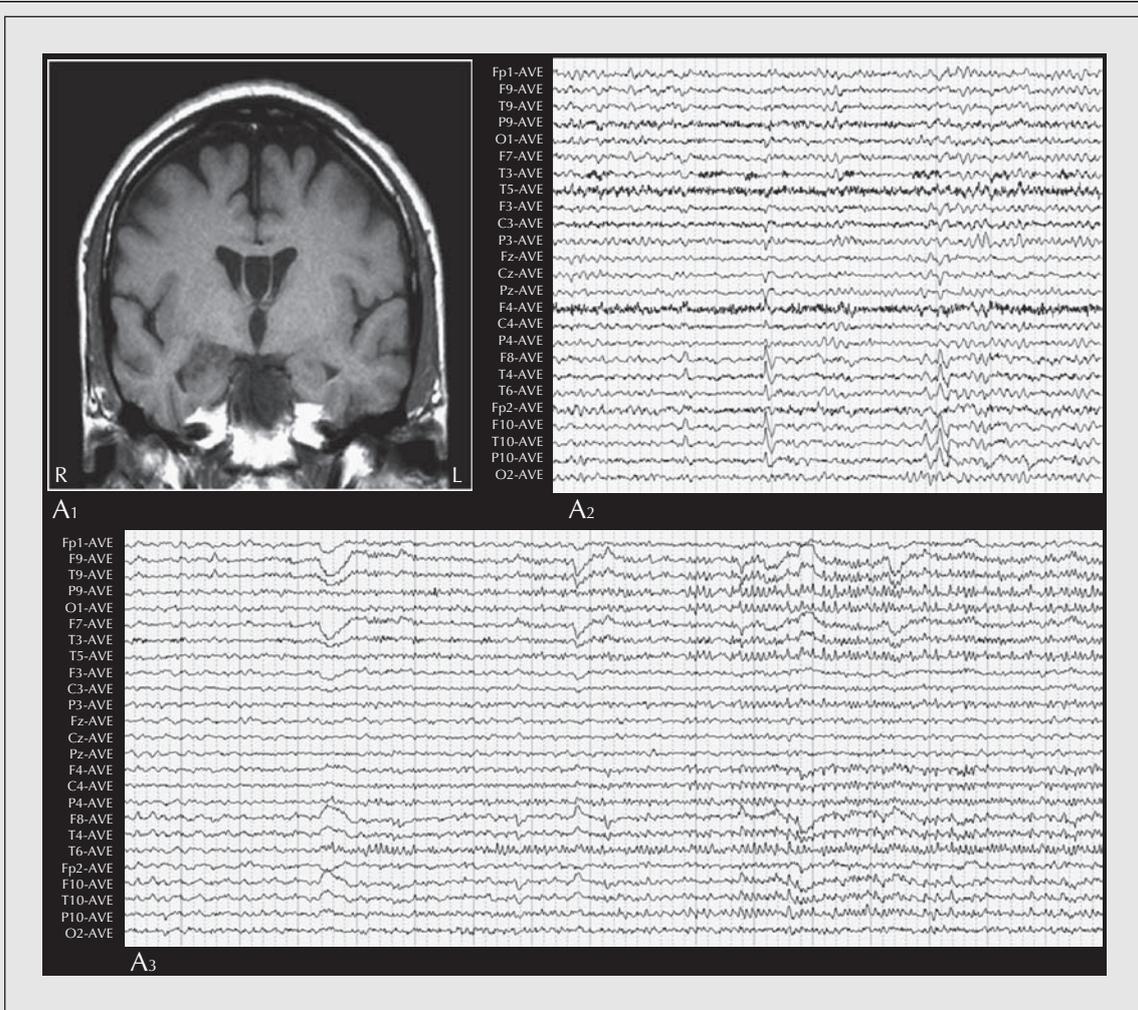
Patient 7. (A₁) MRI revealed a right medial temporal lobe mass lesion. (A₂) Interictal EEG shows a right anterior temporal interictal sharp wave focus (F8/F10 and T4/T10). (A₃) Ictal EEG demonstrates focal onsets of “alpha” activity from the posterior temporoparietal region (T6 to P4).
